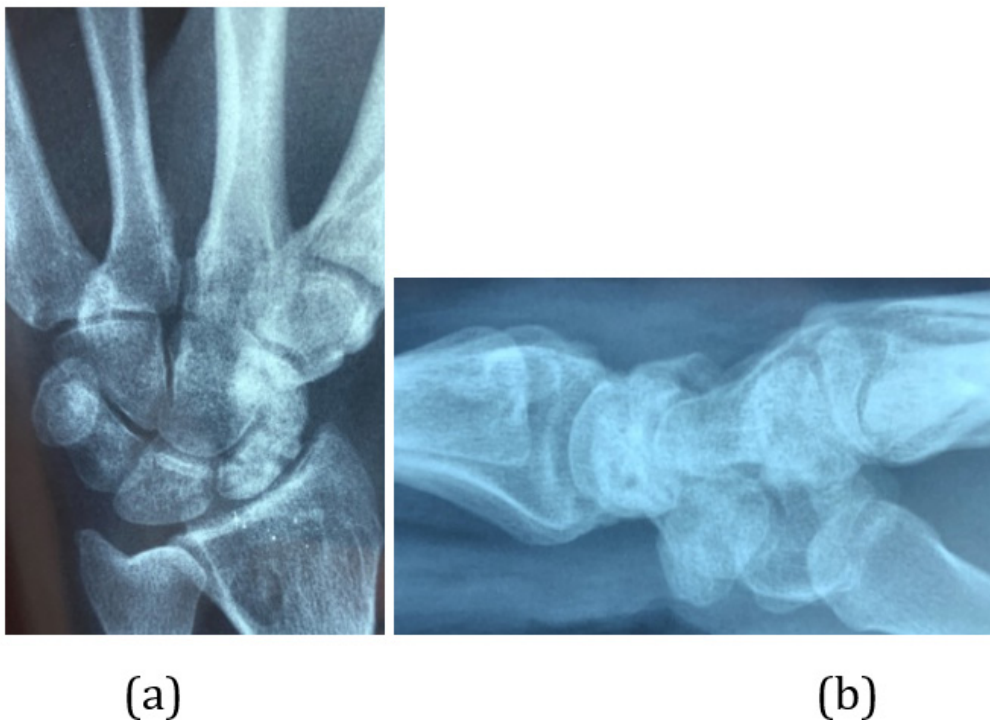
X-Rays views AP(a) and Profile(b) at six months postoperative.
